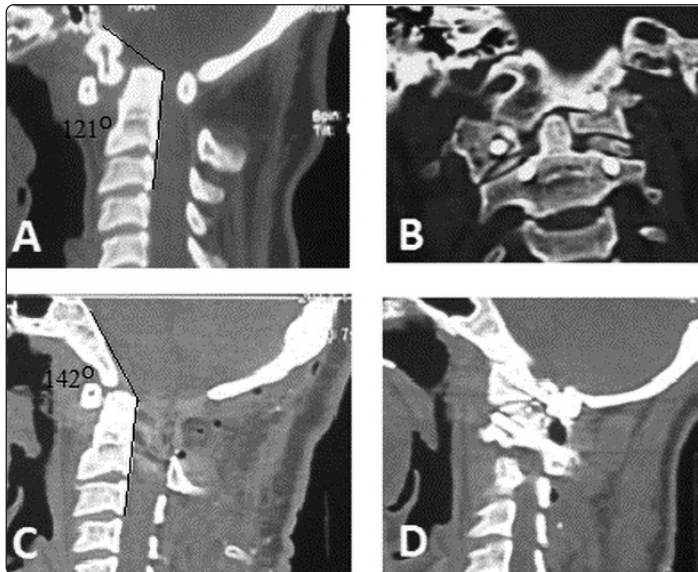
Pre- and postoperative CT scan of (patient no. 3). (A) Preoperative sagittal view noting the basilar invagination and compression of the craniocervical junction and cervicomedullary angle; (B) postoperative coronal view revealing the bone graft at the facets bilaterally, showing the penetration of left occipital condyle; (C) postoperative sagittal view showing the complete reduction of the dens and clivus-canal angle; (D) parasagittal view at the facet joint showing the bone graft at the facets.
